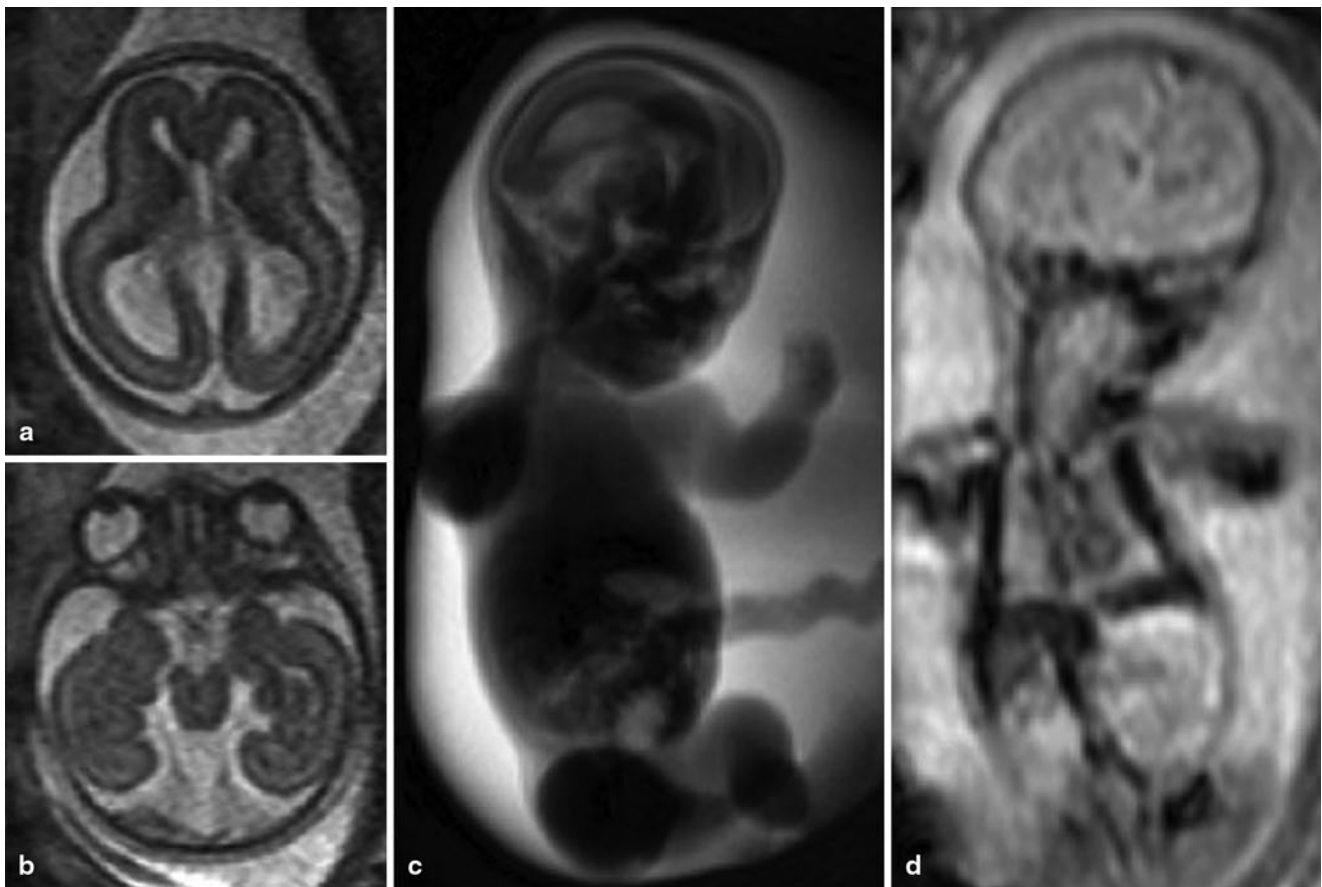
a and b Axial SSFPE images of a fetus at 20+0 GW with thanatophoric dysplasia. In a mild ventriculomegaly can be seen and in b dysplasia of the mesial temporal lobes is evident. c Thick-slab heavy T2-weighted image demonstrates a narrow thorax and short extremities. d Coronal EPI sequence shows the bones as hypointense structures. The right humerus is bowed
